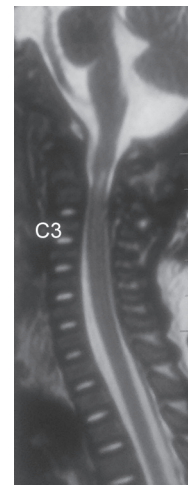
Postoperative T2 image of MRI cervical spine suggestive of good alignment of dens over the body with reduced cord edema
